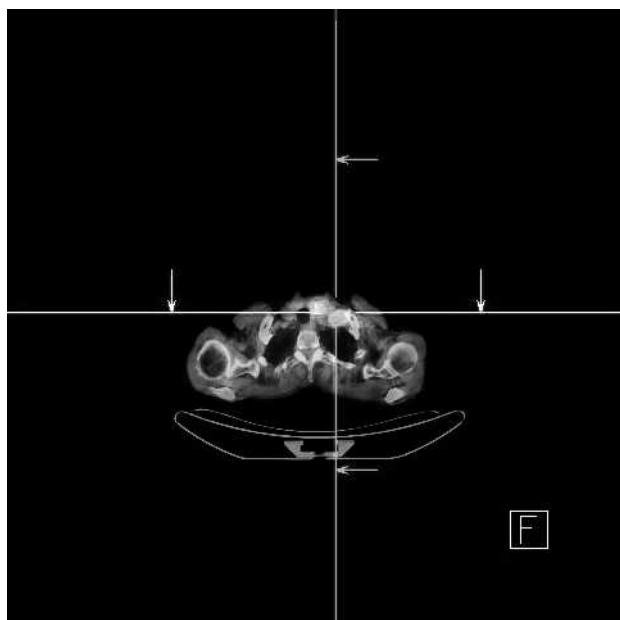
The FDG-PET scan detected a left-sided thyroid nodule and a metastatic lesion in the left cervical region.
